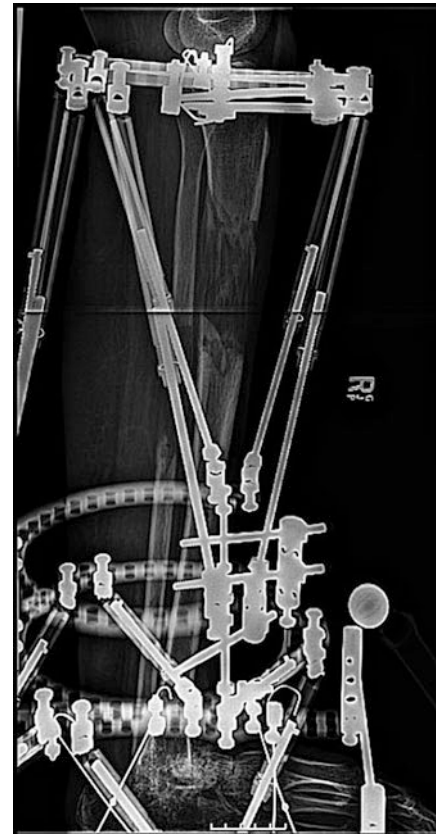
ED radiograph showing distraction of 8 cm
